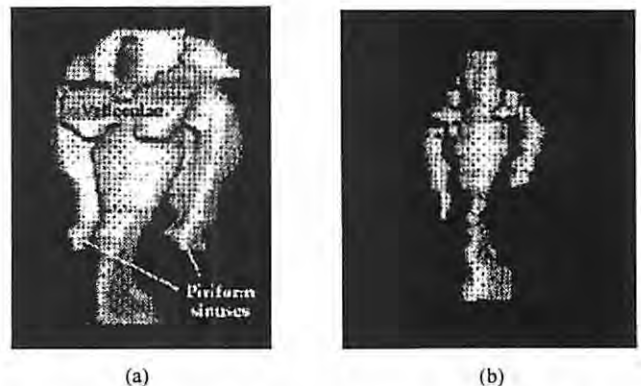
Shaded surface displays of the vowel /a/ expanded in the epi-laryngeal and lower pharyngeal region: a) EBCT, b) MRI.
